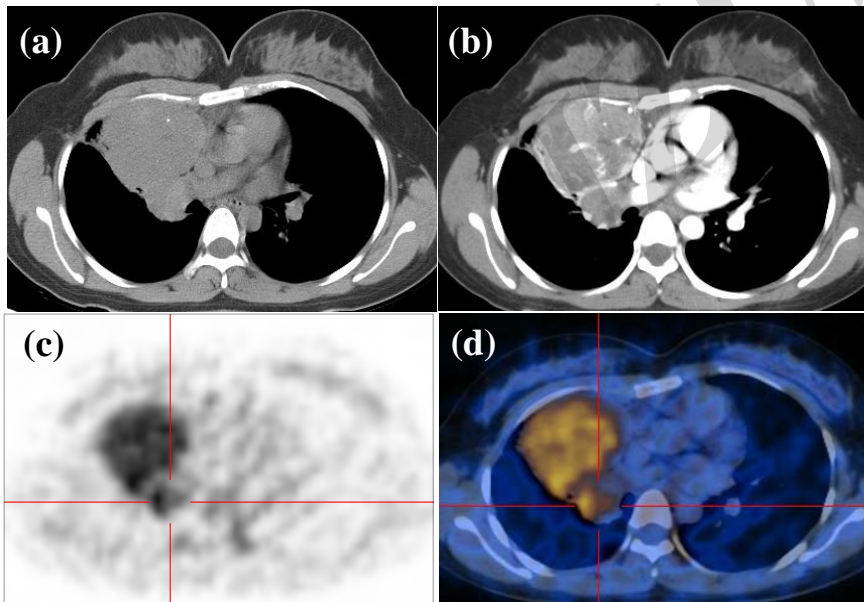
Chest CT axial scan: plain (a) and enhanced (b), showing the right upper lobe tumor. The corresponding PET scan (c) and fused PET/CT scan (d) images show a relatively high uptake of FDG in the tumor ( $\text{SUV}_{\text{max}}=6.1$ ) and lymph node ( $\text{SUV}_{\text{max}}=5.1$ ).
